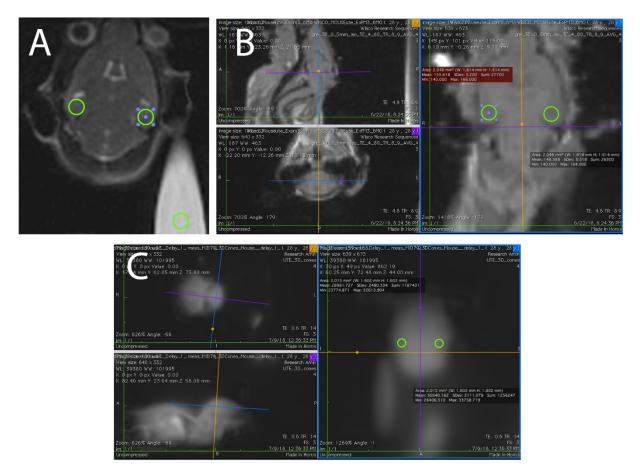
MRI Signal Intensities. ROI's with an area of 2mm squared were chosen over hippocampi (bilateral). And then normalized to a water standard included in each scan. (A) T2\* TSE ROI on left and right hippocampus and the water standard in the bottom right hand corner. (B) GRE ROI over bilateral hippocampi. The crosshair pattern is noted and replicated in the following UTE scans. (C) UTE ROI example. Due to lack of resolution, the pattern for the GRE scan is replicated to zero in on the bilateral hippocampi. The water standard is easily discerned in all of the scans, and aids in orientation as the UTE sequence flips the orientation of the scan in relation to the GRE scan.
